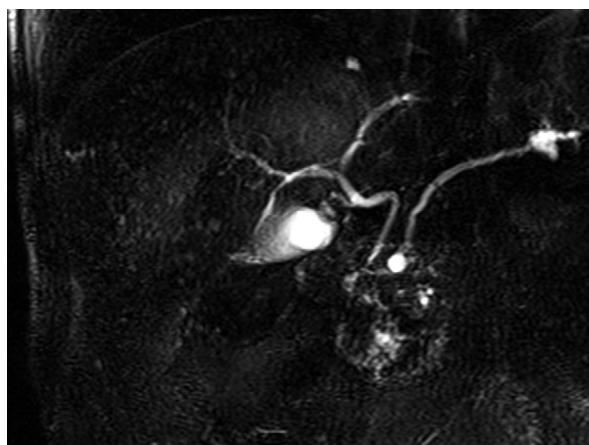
MRI image with T2 MRI-cholangiography sequence: multiple small hyperintense lesions; the liver with a "starry sky" appearance.
